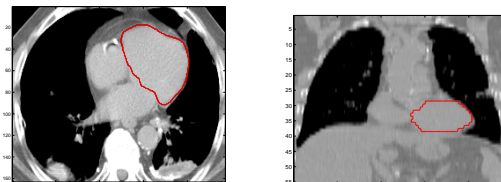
Non-contrast CT thoracic images with manual heart segmentations.
